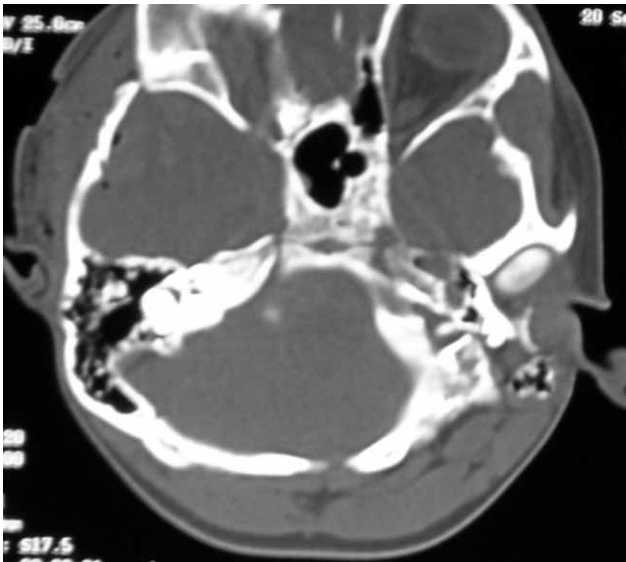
Fragmented fracture with contusion is shown on the squamous part of the right temporal bone in CT scan.
